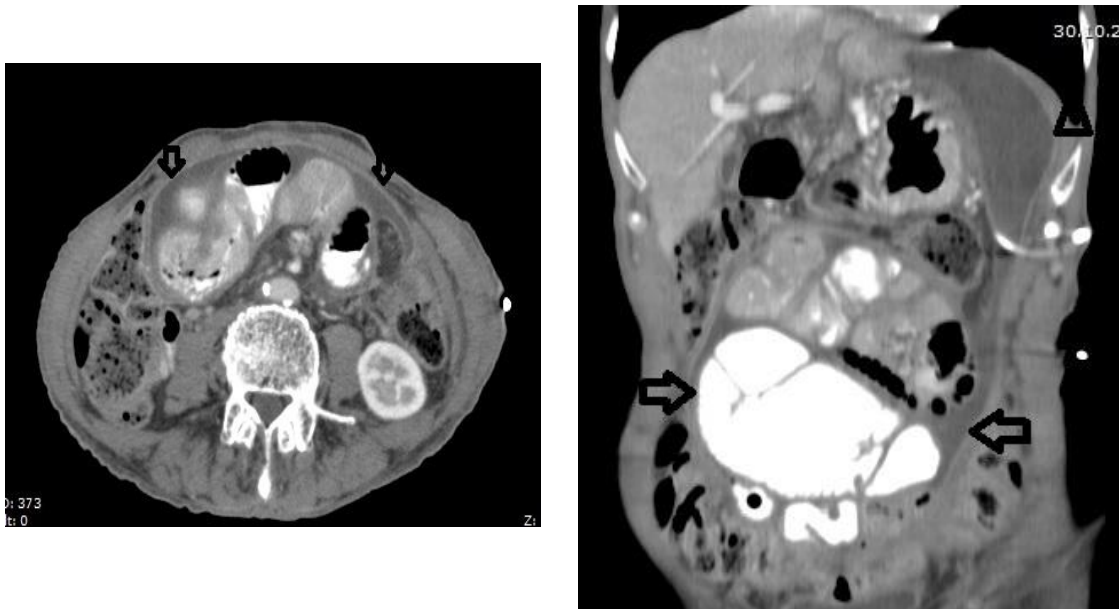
A) Axial oral and IV contrast-enhanced CT shows dilated bowel loops encased thick peritoneal membrane (arrow). B) Coronal oral and IV contrast-enhanced CT shows dilated bowel loops encased thick peritoneal membrane (arrow). Fluid collection with Thick capsule is noted in the left upper quadrant (arrowheads)
